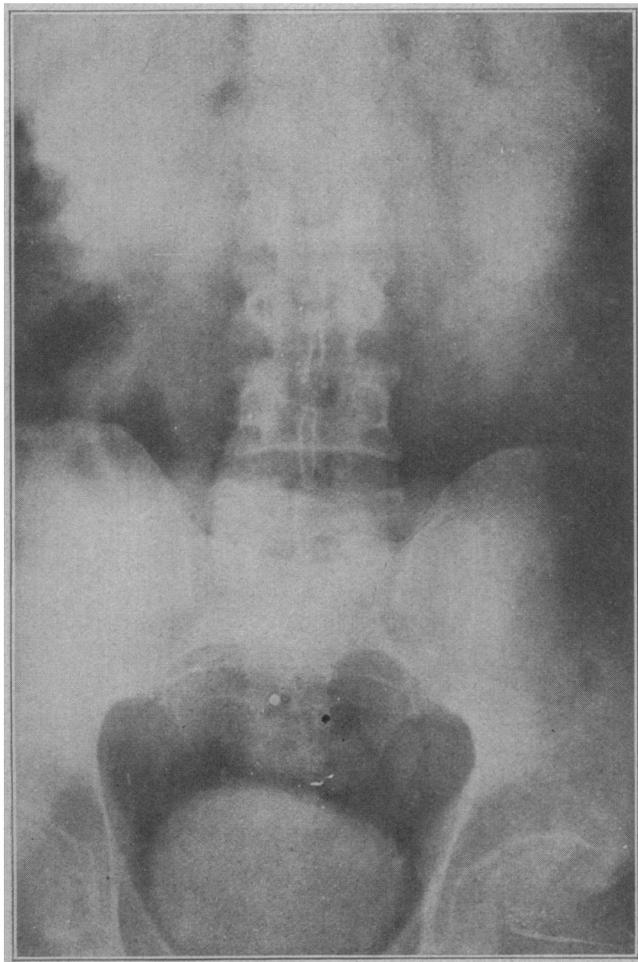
The patient received 100 c.c. of a 10 per cent. solution of sodium iodid intravenously. The roentgenogram made one and one-half hours later revealed a perfect outline of a full bladder, and an outline of the pelvis of the left kidney with a suggestion of the calices and the ureter for a distance of from 3 to 4 cm. below the hilum of the kidney. The right kidney area was obscured by gas in the colon.
